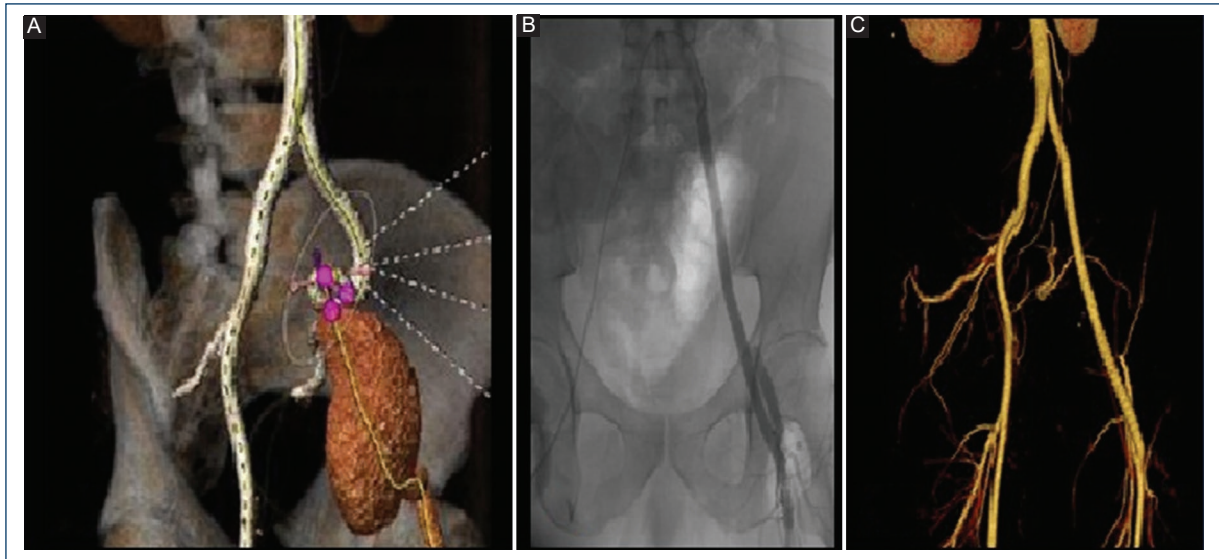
A: 3D computed tomography angiography of AII with a 13-mm proximal neck, a 90-mm maximum aneurysm diameter, and a 12-mm distal neck. B: intraoperative arteriography showing end-lateral iliac femoral bypass with PTEE graft, adequate passage of contrast medium. C: 3D CT angiography at 3 months.
